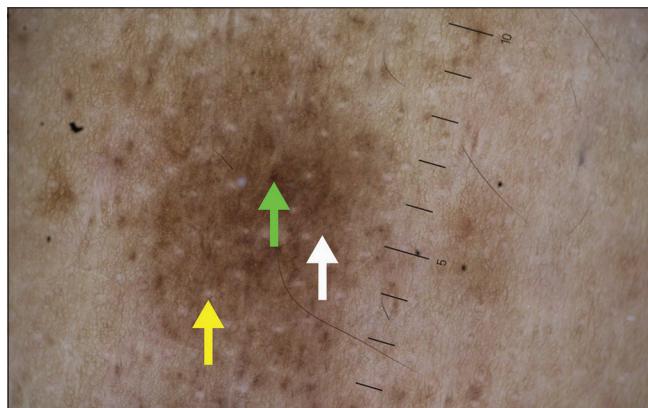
Resolved classical lichen planus. Polarised light dermoscopy after application of ultrasound gel of resolved classical lichen planus showing brown-black dots (green arrow), with diffuse brown pigmentation (white arrow) and white dots (yellow arrow) (original magnification, $\times 10$)
